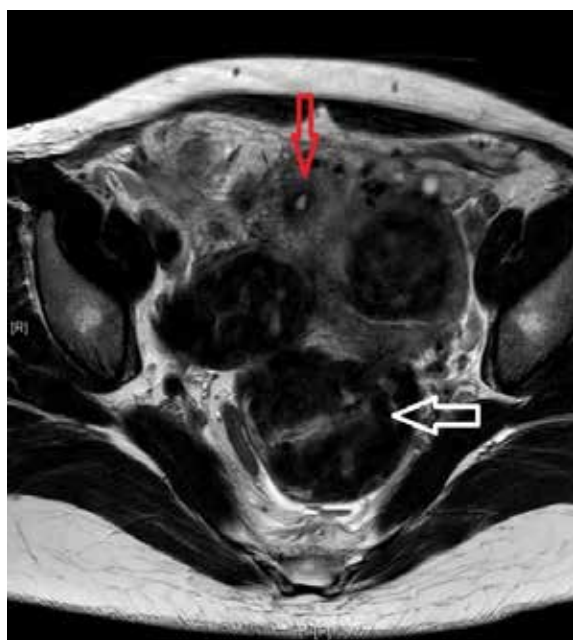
Transverse view of T2 weighted MRI shows FIGO Type-7 fibroid (white arrow) arising from the posterior uterine wall occupying the rectouterine pouch. Endometrial cavity shown with red arrow head
